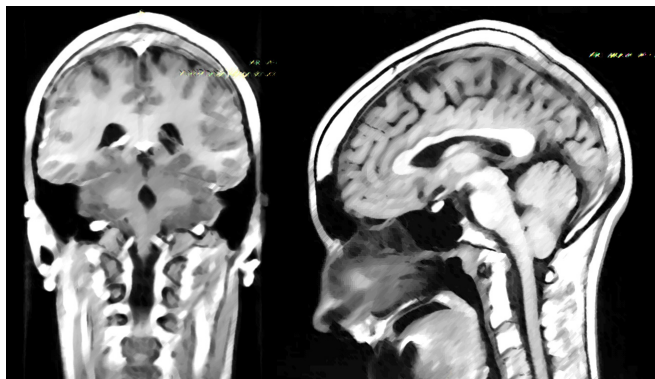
MRI brain demonstrating dilation of lateral and fourth ventricle (coronal view) and cerebellar tonsillar herniation (sagittal view).
